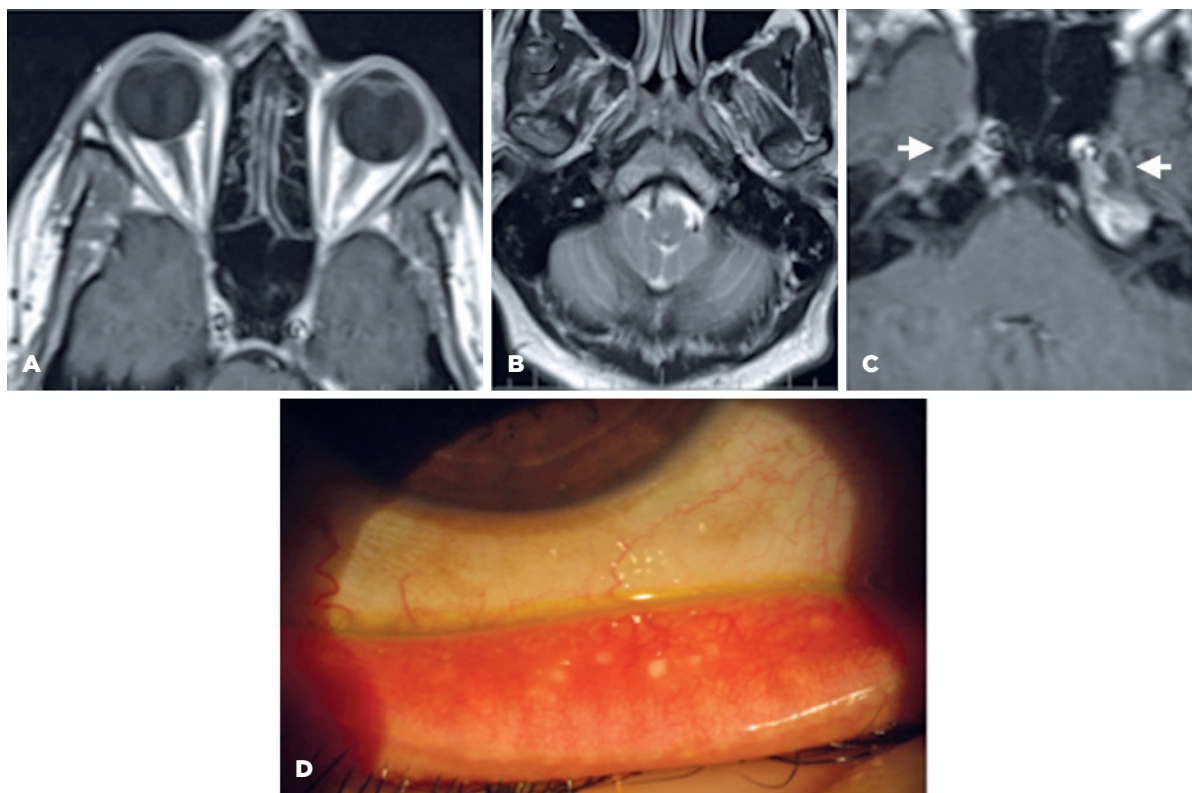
Case 2. A. Axial T1-weighted magnetic resonance (MR) image at the upper level of the orbits shows the absence of the lacrimal glands. B. Axial T2-weighted image shows the absence of the parotid gland. C. T1 axial oblique plane shows the cisternal portion of the trigeminal nerve (arrows). D. The tarsal conjunctiva shows hyperemia and conjunctival concretions.
